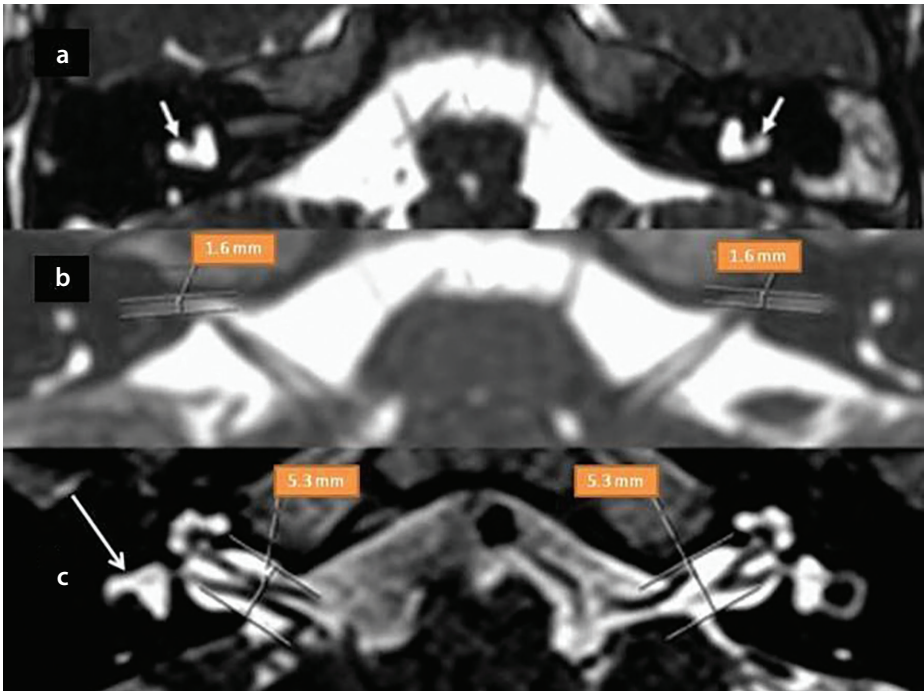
Three-dimensional T2-weighted SPACE magnetic resonance images in the axial plane. A 3-year-old boy with bilateral lateral semicircular canal (LSCC) aplasia shows bud-like structures (a, arrows) and bilateral narrow internal auditory canals (IACs) (b). (c) A 2-year-old girl shows a bud-like formation of the right LSCC (arrow) with dysplastic and hypoplastic canal structures; the IAC diameters are normal.
